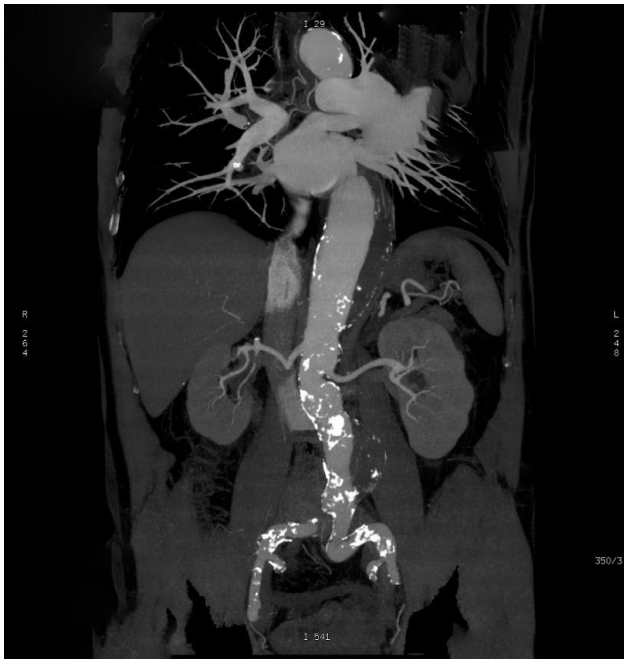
Preoperative computed tomography (CT) of the patient with type III thoracoabdominal aortic aneurysm (ThAAA).
